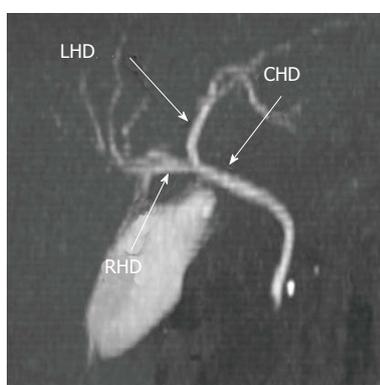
Maximum intensity projection image generated from a computed tomography cholangiogram. Normal biliary anatomy is demonstrated here. LHD: Left hepatic duct; RHD: Right hepatic duct; CHD: Common hepatic duct.
